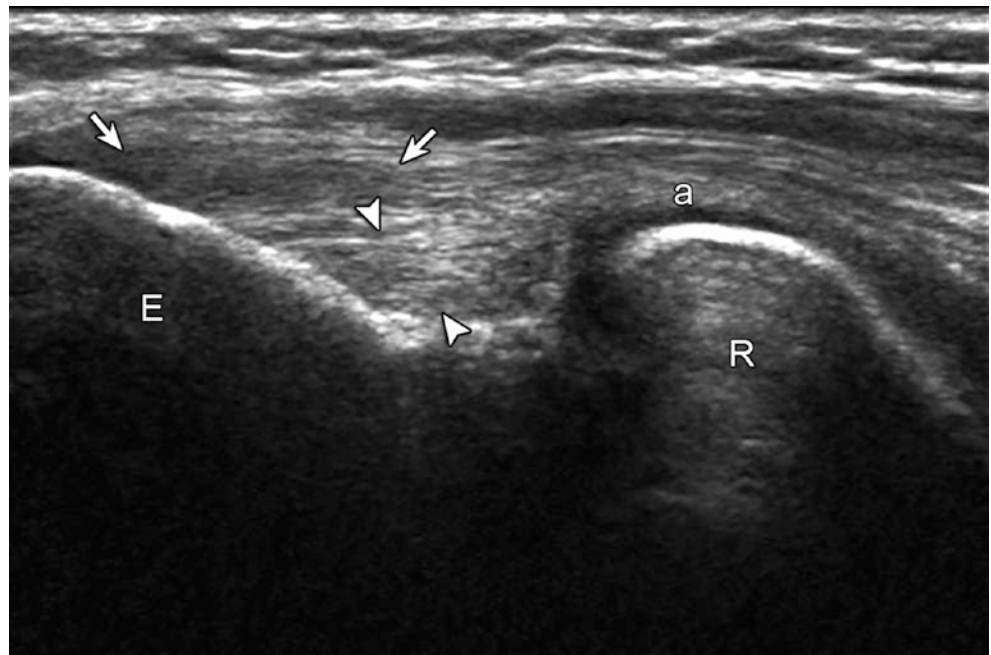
Common extensor tendon abnormality (lateral epicondylitis). Ultrasound image long axis to common extensor tendon shows hypoechoic tendinosis (arrows). Note radial collateral ligament proper (arrowheads). *E* lateral epicondyle, *R* radial head, *a* annular ligament
